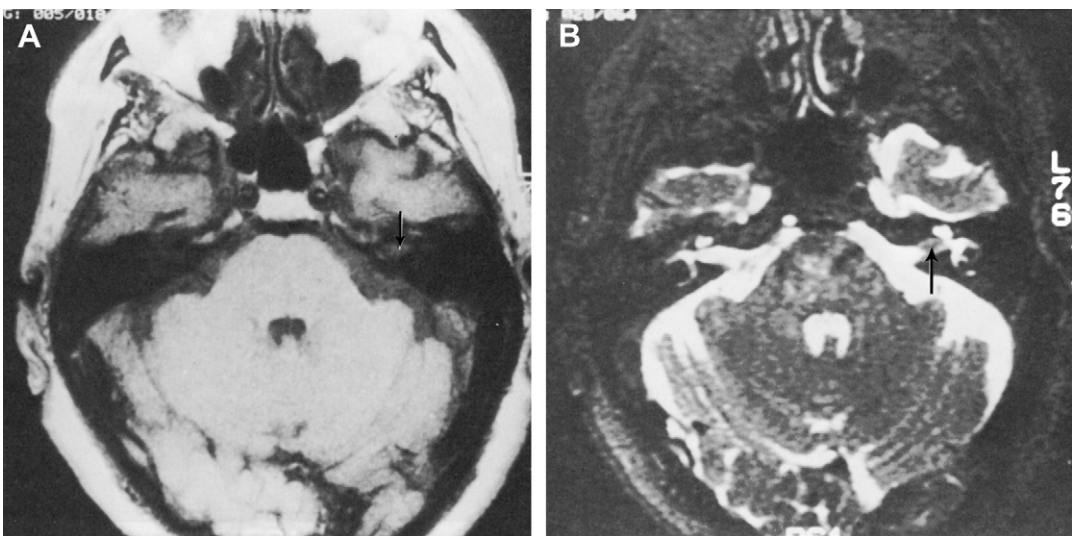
(A) T₁-weighted magnetic resonance image (without gadolinium). There is a slight increase in signal on the side of the acoustic neuroma (*arrow*). This would be difficult to call positive with certainty. (B) On a T₂-weighted image the cerebrospinal fluid (CSF) is bright white. The tumor now shows as an area of low signal (*arrow*) contrasted against the CSF. Compare with the CSF-filled internal auditory canal on the normal side.
